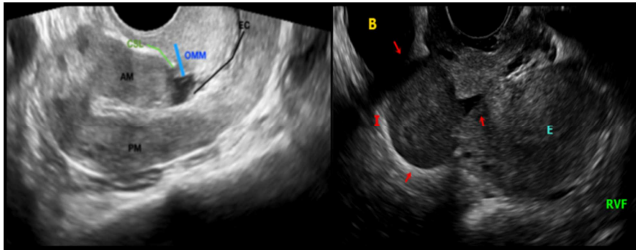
Ultrasound View. Hipo-echoic cyst-like formation within the anterior cervical isthmus wall in the C-section scar site. In a close look it is possible to identify the anatomical parts of the Isthmocele. TMT: Total myometrial thickness. OMM: Overlying myometrial mantle. AM: Anterior myometrium. PM: Posterior myometrium. EC: Endocervical channel. B: Bladder. E: Endometrium. RVF: Retroversoflexion.
